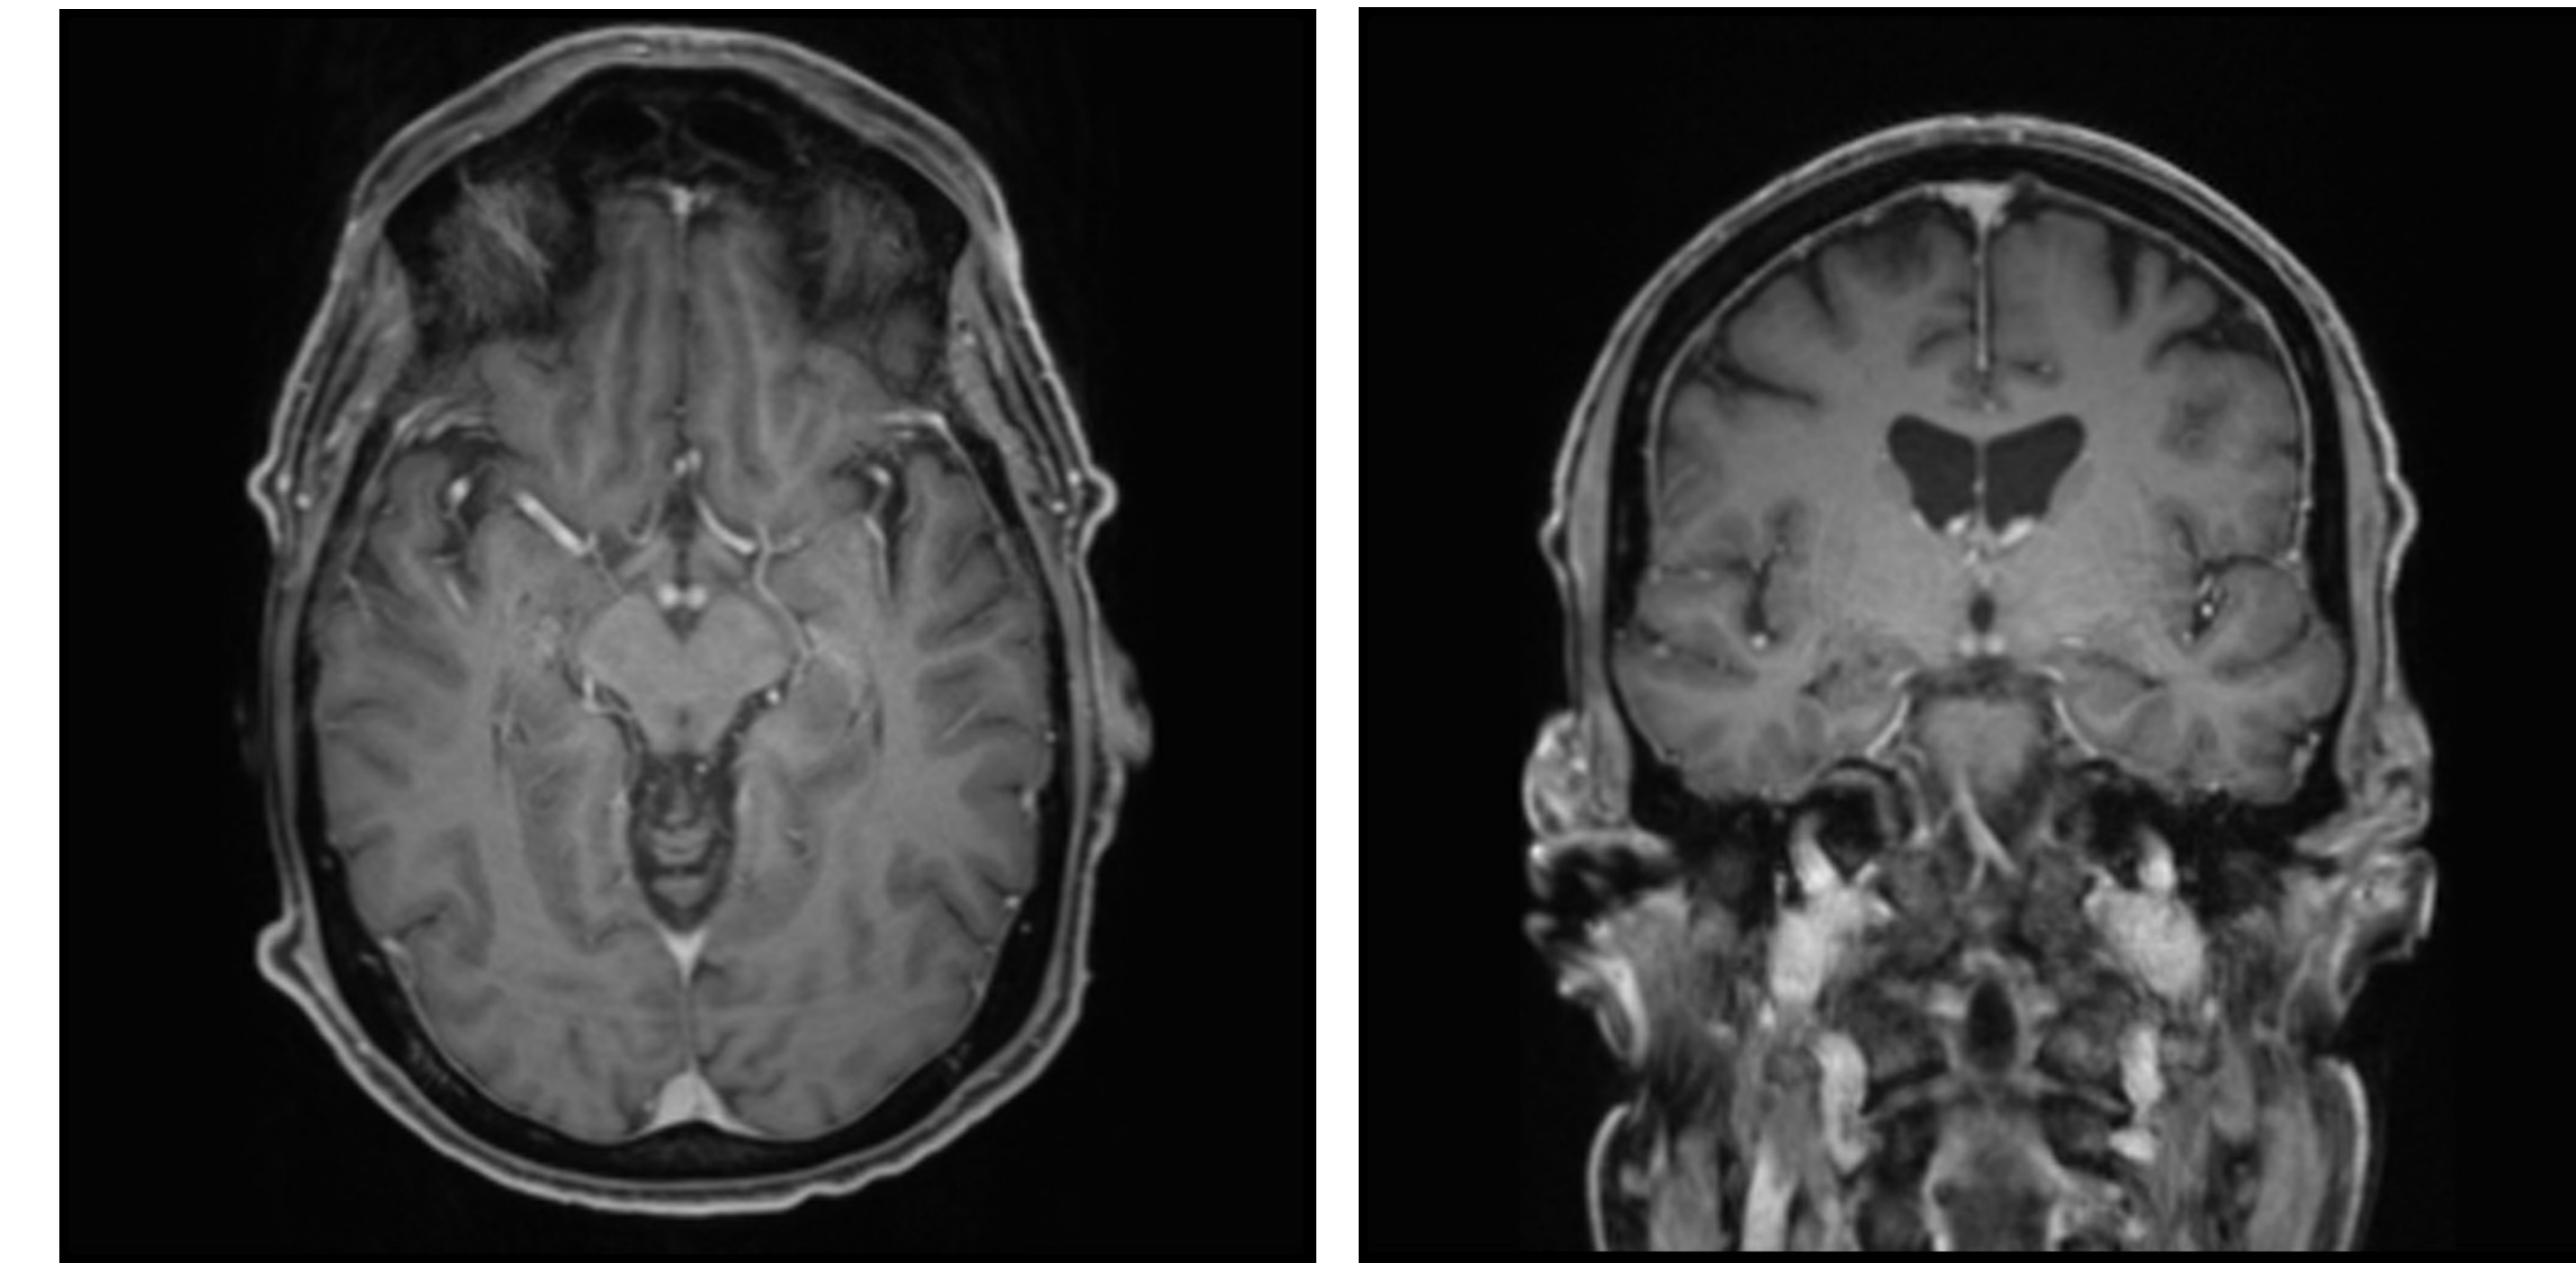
MRI, Axial T1 C+. Mammillary bodies are a region of high oxidative metabolism, and thus, enhancement can be seen in thiamine deficiency.
